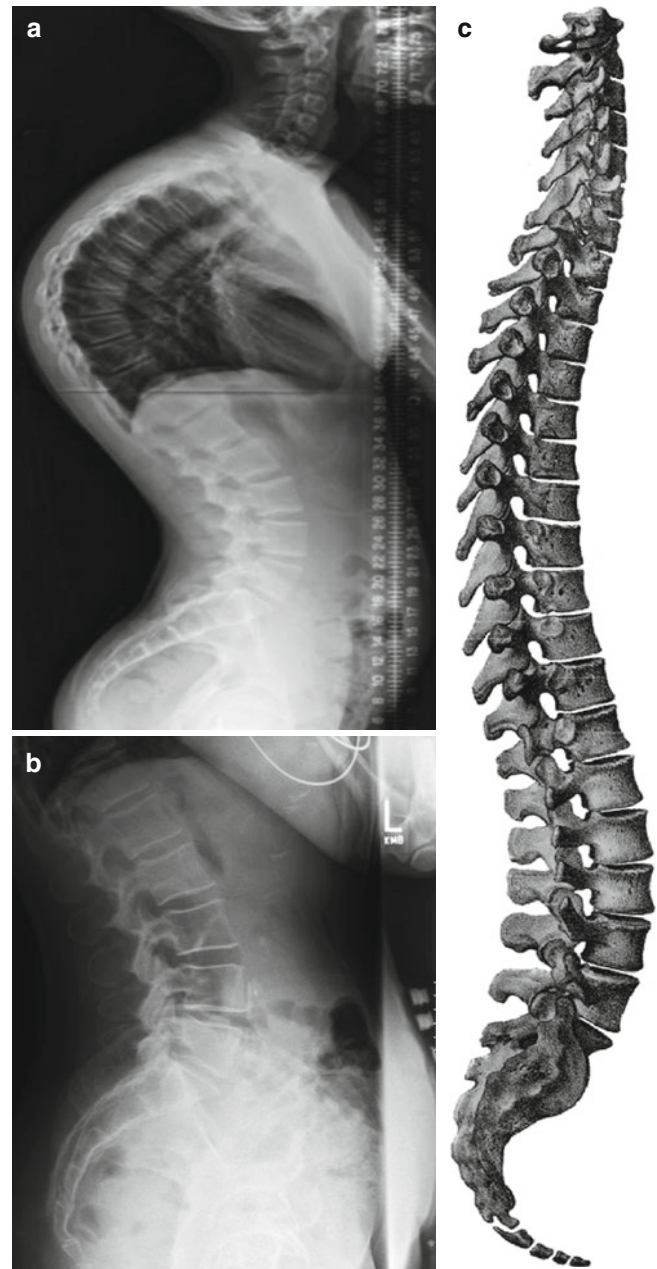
Spinal curvature: kyphosis and lordosis. Anterior-posterior radiographs of the spine showing (a) kyphosis (excessive posterior bending of the thoracic motion segments) and (b) lordosis (extreme anterior bending of the lumbar and often the cervical spine). (c) The complete spine showing the natural curvature in the cervical, lumbar, and sacral regions (From Bougery and Jacob (1833). Plate 6)
